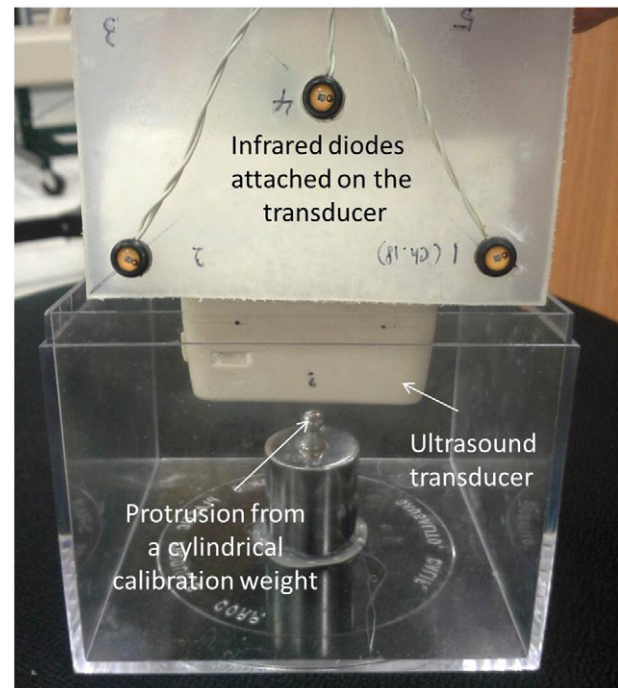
The experimental setup for validating the ultrasound-based system to digitize spatial positions. (Color version of figure is available online.)
